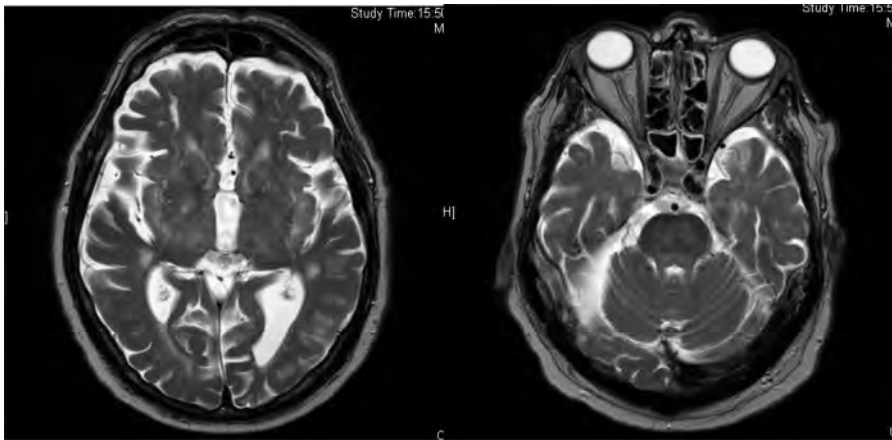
Wernicke's syndrome. T2-weighted MRI showing high intensity lesions in the medial thalami and peri-aqueductal grey matter of the midbrain.
